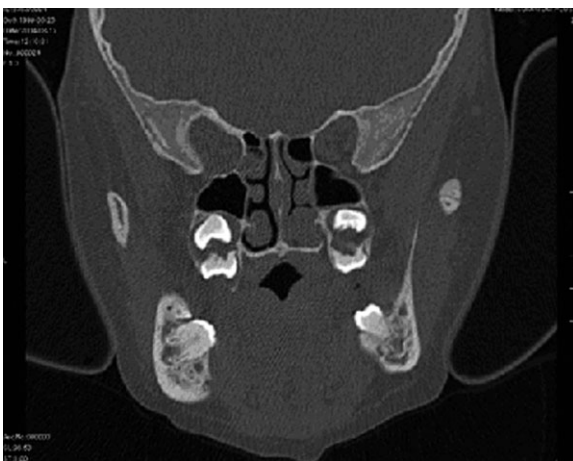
CT examination – unerupted misplaced teeth in the maxillary sinuses.
